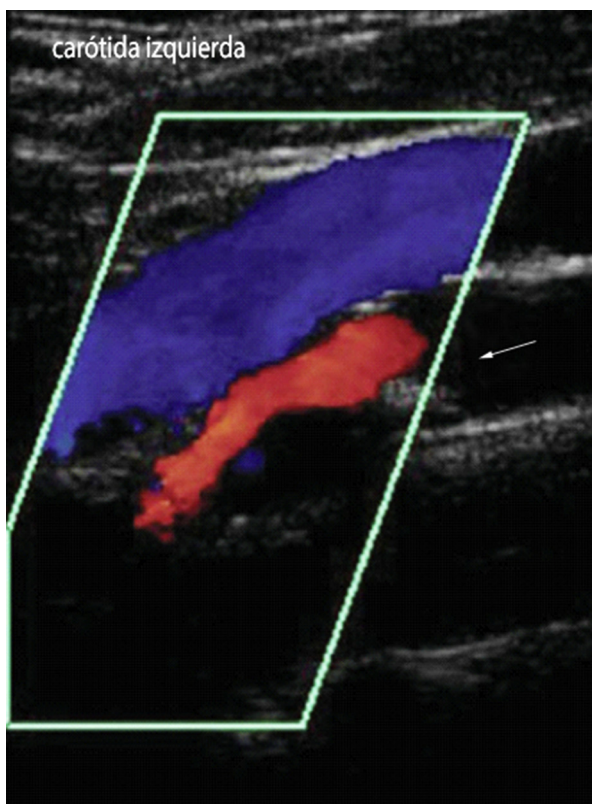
Doppler ultrasound scan of the carotids showed 80%-90% left internal carotid artery stenosis. The arrow is pointing at the left internal carotid artery ICA obstruction showing an 85% stenosis.
